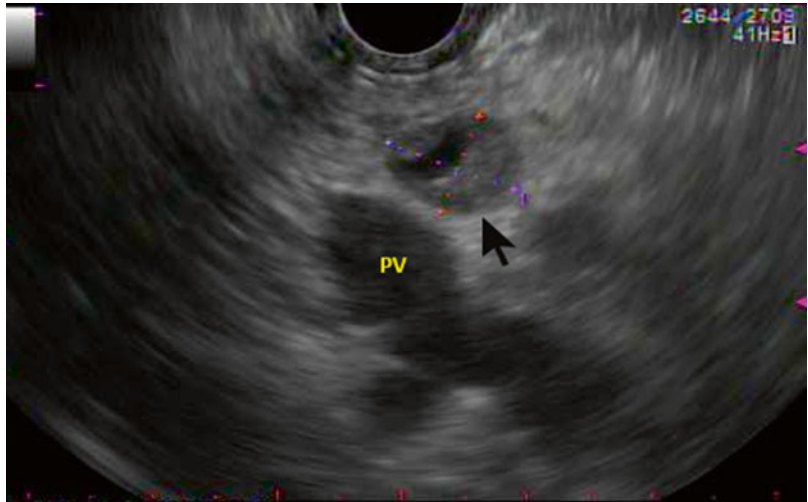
Radiological characteristics of cystic pancreatic neuroendocrine tumor (CPNET). CT showed a low-density lesion measuring 1.0 cm with a thick wall at the junction of the pancreatic body and tail (*black arrow*)
